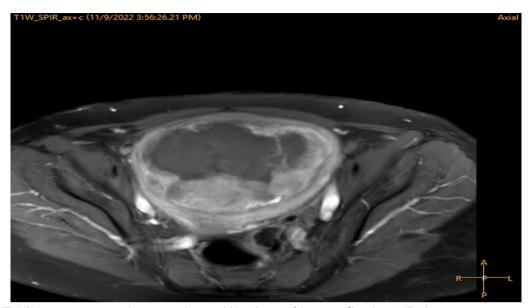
Axial T1 MRI Image post-contrast shows non-enhancing (ablated) areas of the uterine fibroid post-HIFU therapy
